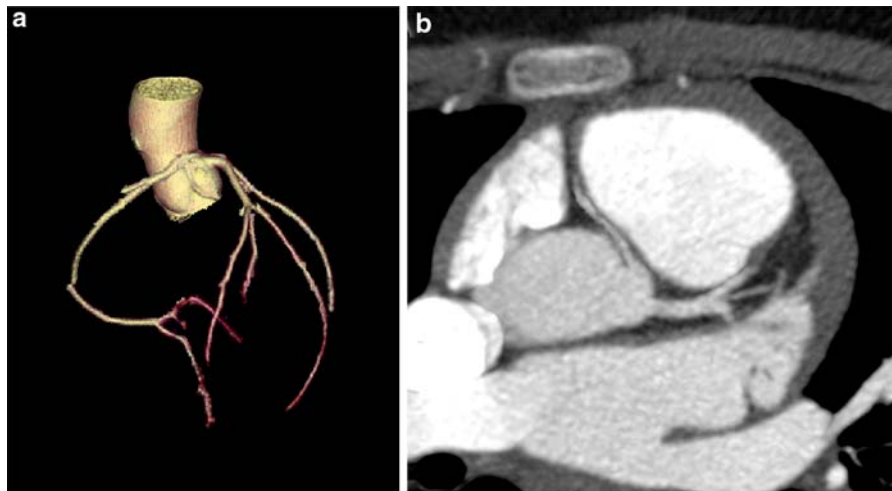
Very low dose (0.84 mSv) prospectively gated CCTA performed on a 12-year-old girl with chest pain and an abnormal cardiac echocardiogram. 3D volume rendering of the coronary arteries depicts a anomaly of the RCA which arises
